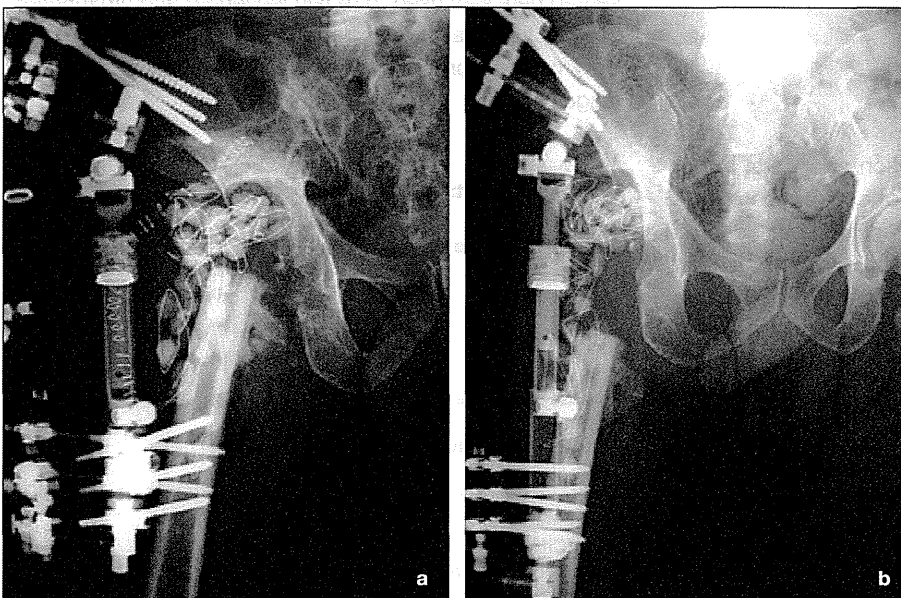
AP radiograph: a) just after the initial surgery; b) at 2 months after the initial surgery.
